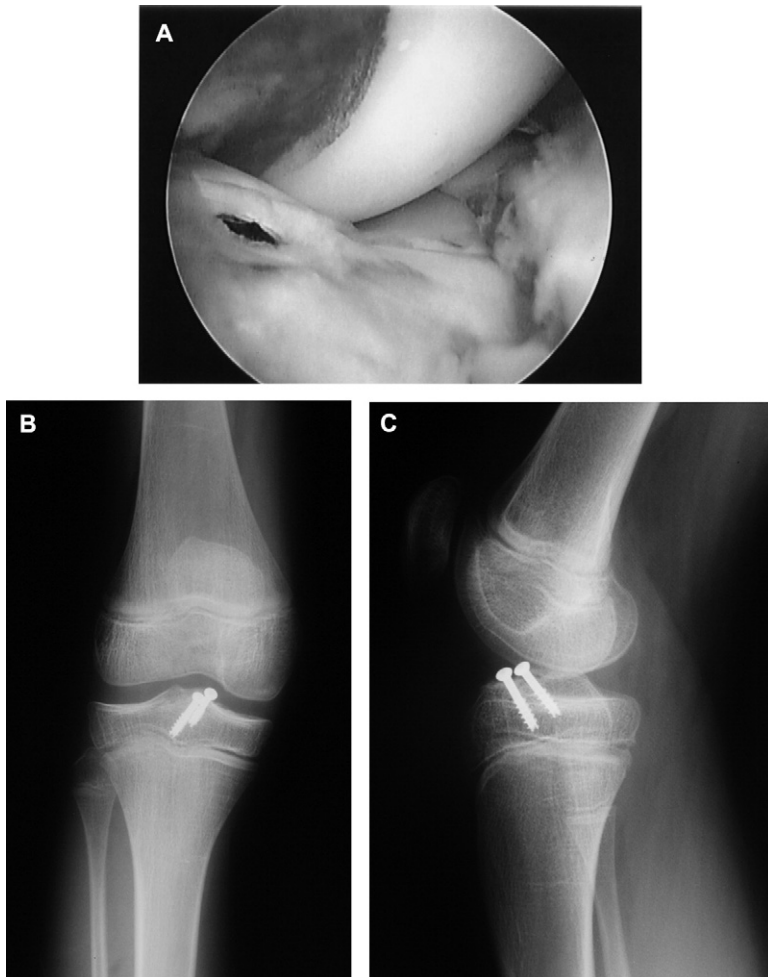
(A) This arthroscopic view shows the fracture after fixation with 2 cannulated screws. (B, C) The corresponding radiograph demonstrates reduction of the fragment.
